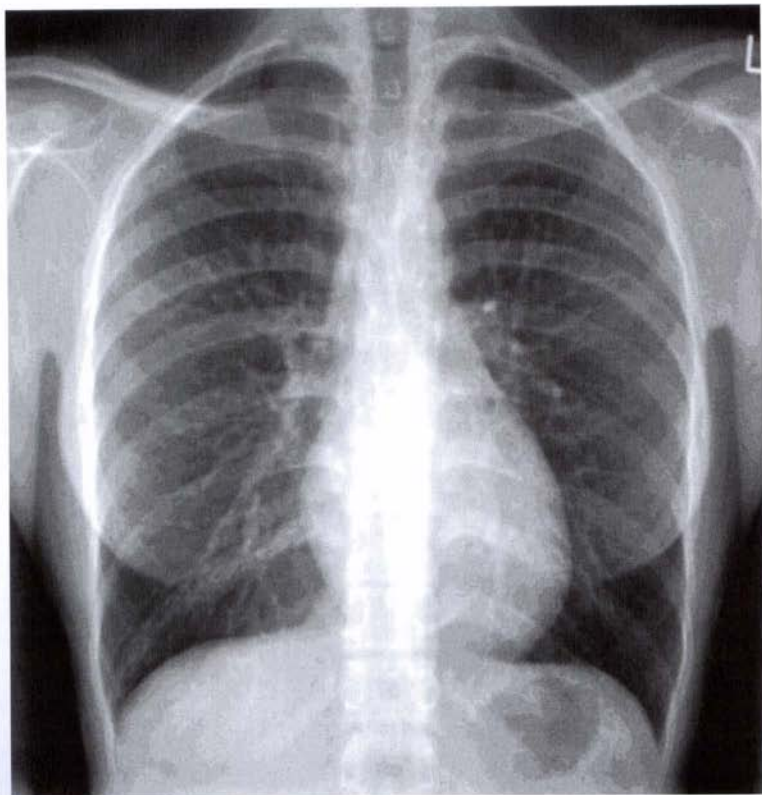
Normal chest X-ray
